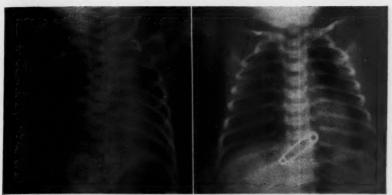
A. (Left hand side) Roentgenogram of 3 day old infant with obstructive atelectasis of the left lower lobe. B. (Right hand side) Roentgenogram of same infant shown in figure 1A 1 hour after bronchoscopy.
